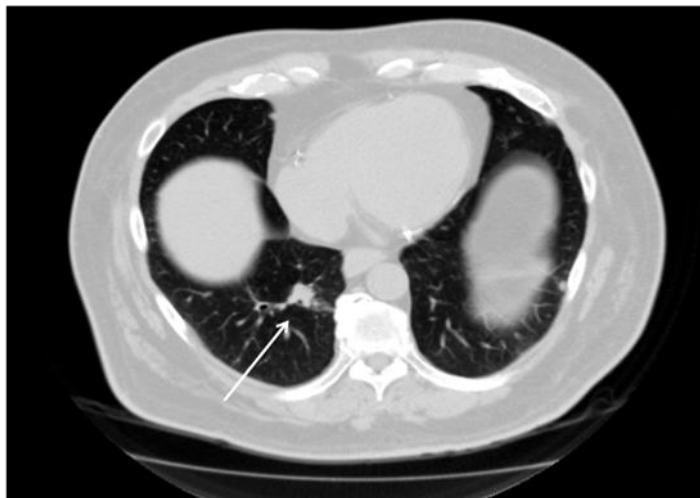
CT scan done 6 months after biopsy (9 months after original CT scan). The right lower lobe lesion appears smaller at 1.2 cm.
